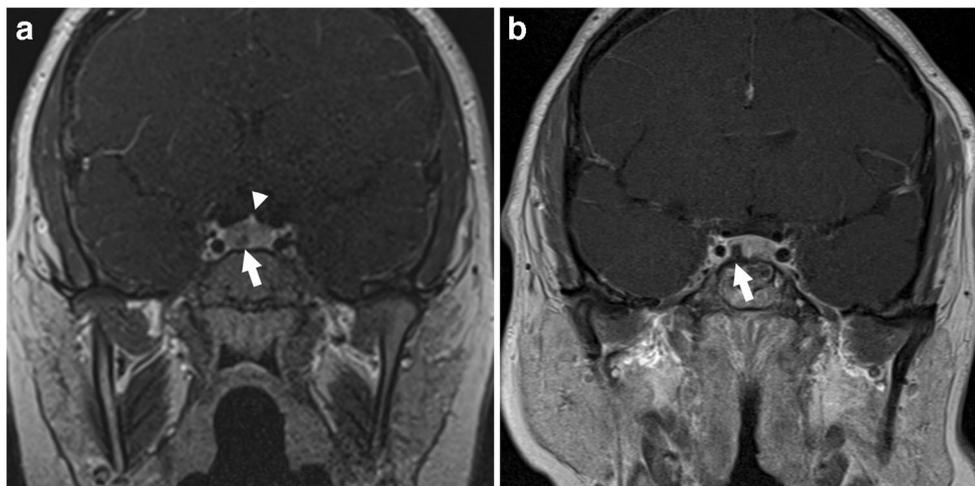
a Imaging localization of an adenoma in Cushing's disease. In this coronal T1-weighted MRI with contrast, rapid sequencing of slices through the pituitary gland during contrast administration demonstrates delayed or absent uptake of contrast in the adenoma. Arrow indicates adenoma, positioned in the inferior right aspect of the gland. Arrowhead indicates the pituitary stalk. b Resection of secretory adenoma
